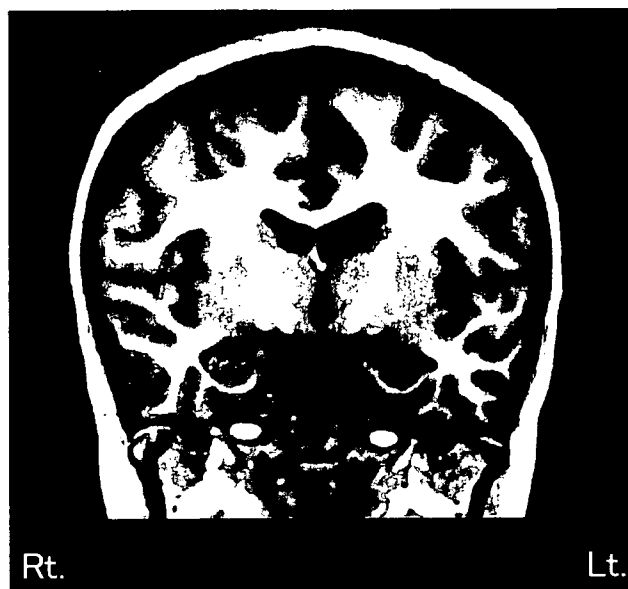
統合失調症患者 (19 歳, 女性) の MRI
